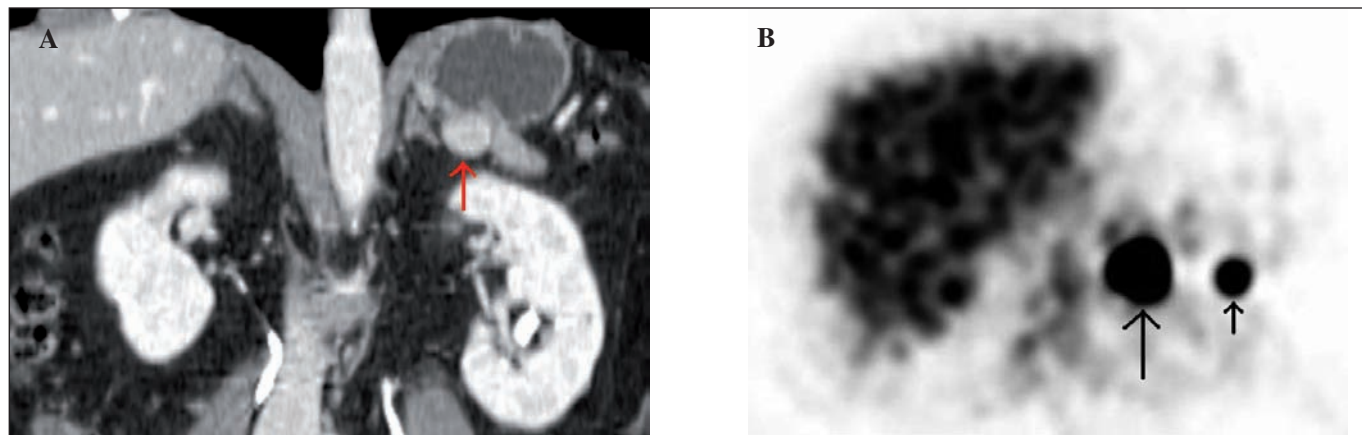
A. CT scan shows nodular lesion (red arrow) on the greater curvature of the gastric body suggestive of gastric splenosis. B. Same lesion (large arrow) as figure 2A seen on scintigraphy with technetium 99m-labelled red blood cells. A smaller focus of peritoneal splenosis (small arrow) was also identified.
